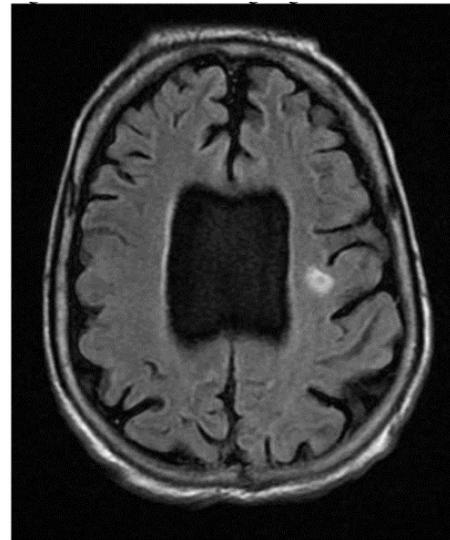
Head MRI showing single oval lesion in the left cerebral hemisphere.
